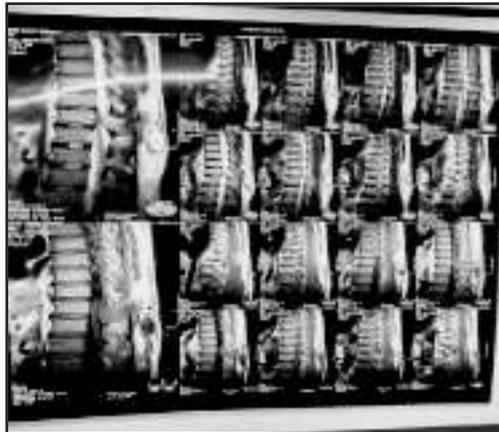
MRI of dorsal spine showed expansile destructive lesion in posterior element of D11 vertebra with extension into spinal canal causing indentation of thecal sac, narrowing of spinal canal & compression of spinal cord at this level
